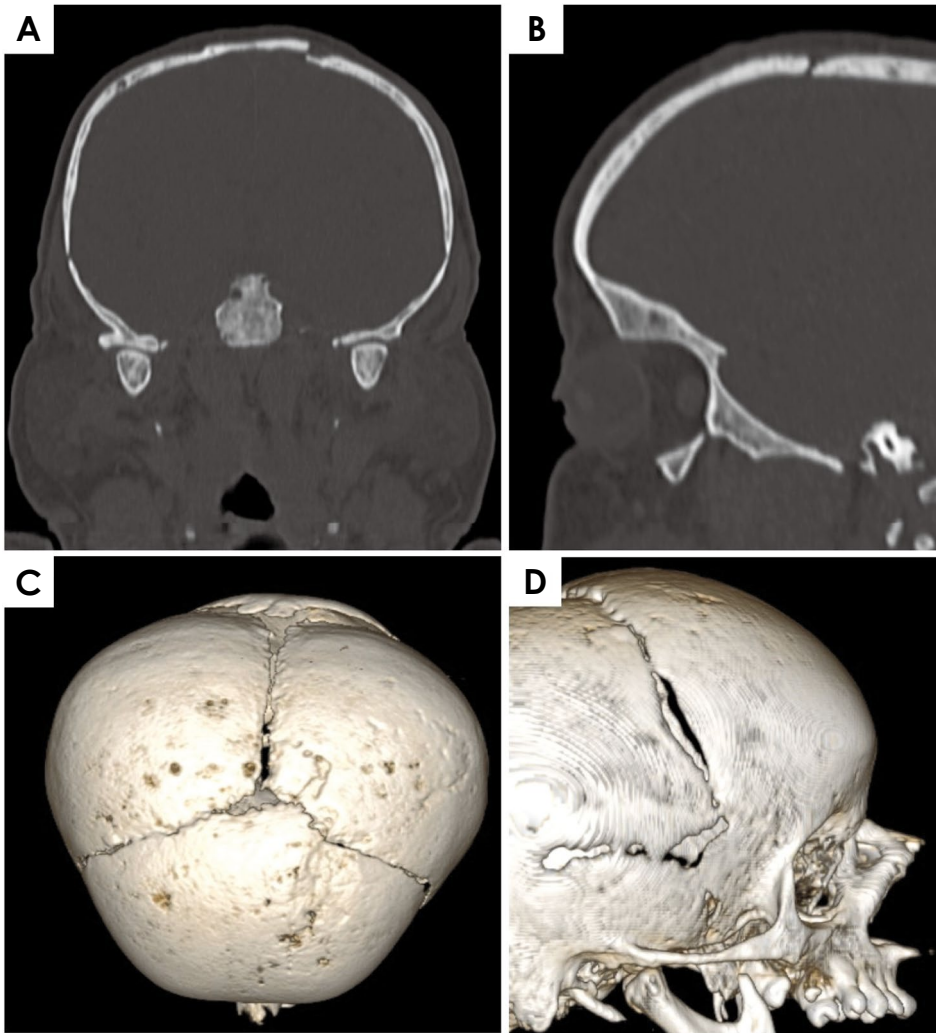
Discontinuity of the cranial vault is evident on cone-beam computed tomography coronal (A) and sagittal (B) reconstructions. C and D. Three-dimensional reconstruction images show open sutures and fontanelles, as well as frontal and parietal bosses.
